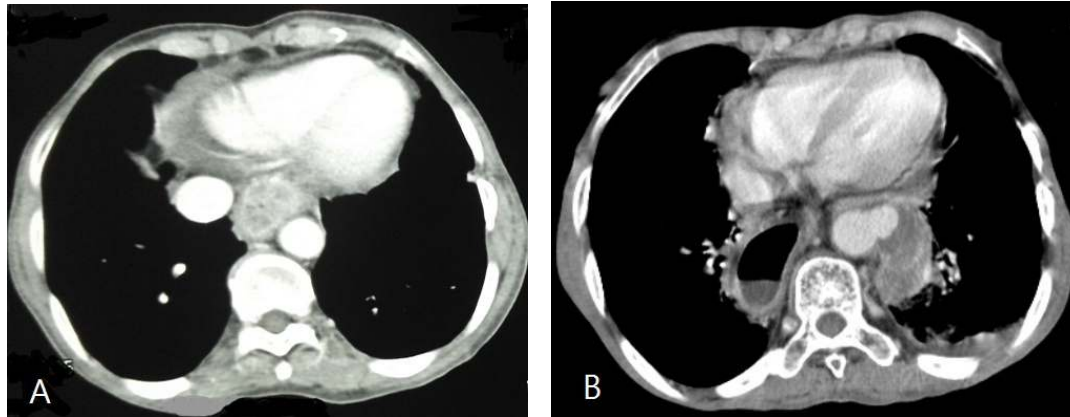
A) Preoperative contrast-enhanced axial CT scan showing esophageal thickening and normal descending thoracic aorta. B) Postoperative contrast-enhanced axial CT scan showing a saccular outpouching with similar density to the aorta in a distal part of descending thoracic aorta with an infective collection around this area
